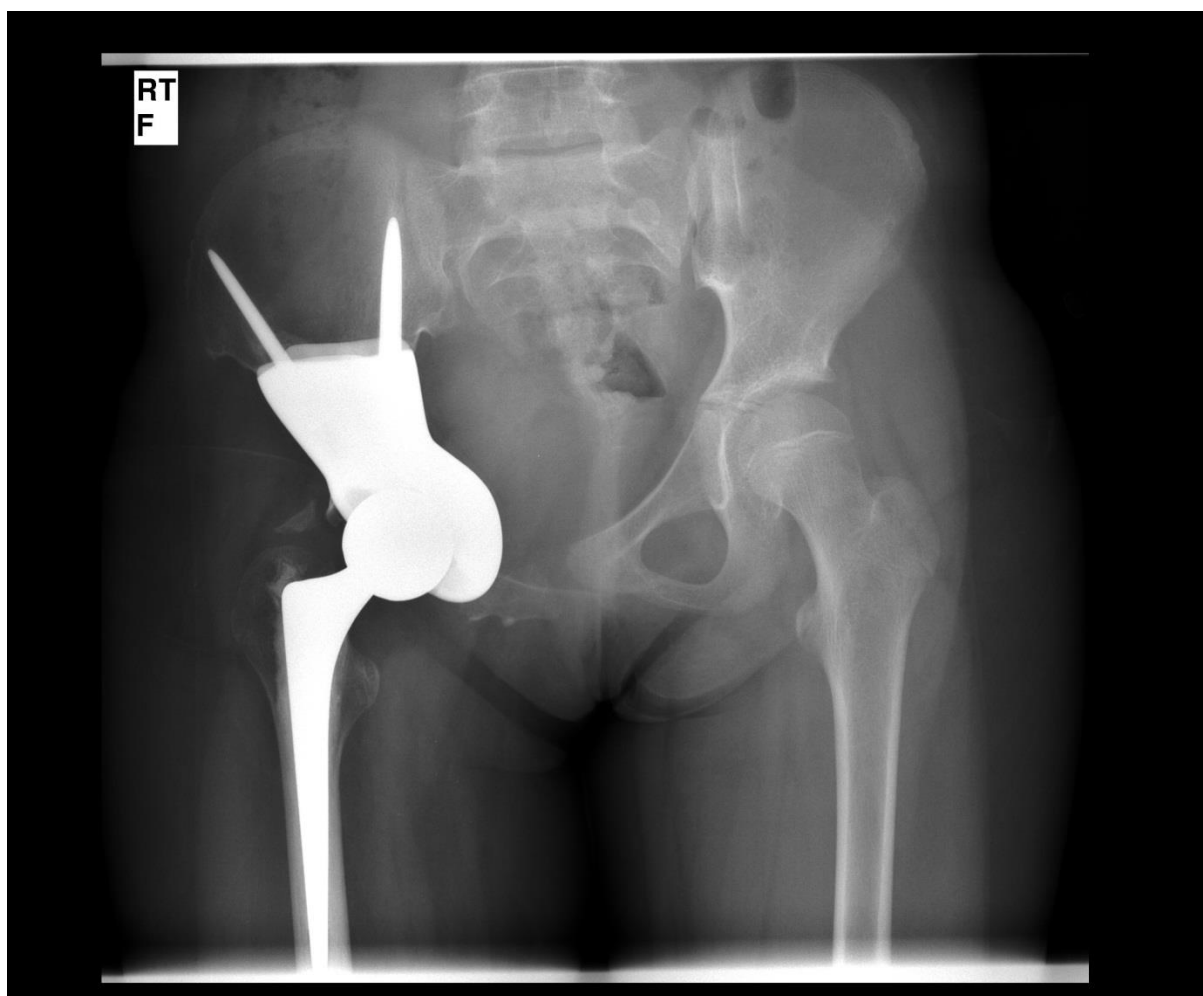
An AP radiograph of pelvis showing an endoprosthetic replacement for a type II tumour
